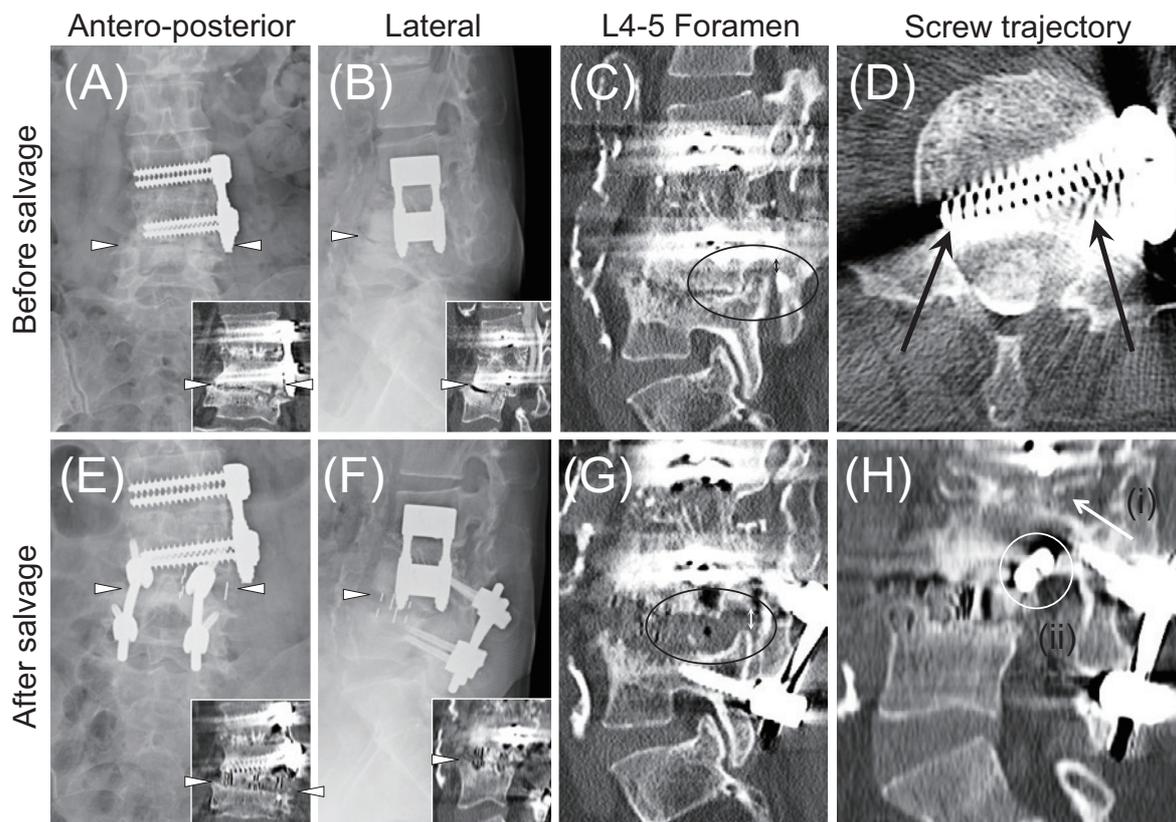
Radiological studies pre- and post-salvage surgery. Ten years after anterior lumbar interbody fusion (ALIF) surgery, the patient complained of robust leg pain in her L4 dermatome area. A-D, Preoperative radiological examination shows caudal adjacent segment disorder with extremely decreased L4-5 intervertebral space (A-B: *arrowhead*) followed by severely decreased L4-5 foraminal height (C: *circled, arrow*). D, Axial plane of the ALIF screw trajectory shows direct interference of the ALIF screw for possible pedicle screw (*arrows*). Lower panels (E-H) show the radiological evaluation 1 year after salvage surgery. E-F, Rigid interbody fusion is confirmed as bony massive bridge within the intervertebral space (*arrowhead*) and (G) major recovery of L4-5 foraminal height has been achieved (*circled, arrow*). H (representative image), The sagittal plane of the computed tomographic image shows the direction of the CBT screw (i, *arrow*) does not interfere with the existing ALIF screw (ii, *circle*: describes perpendicular cross-section of the screw).
